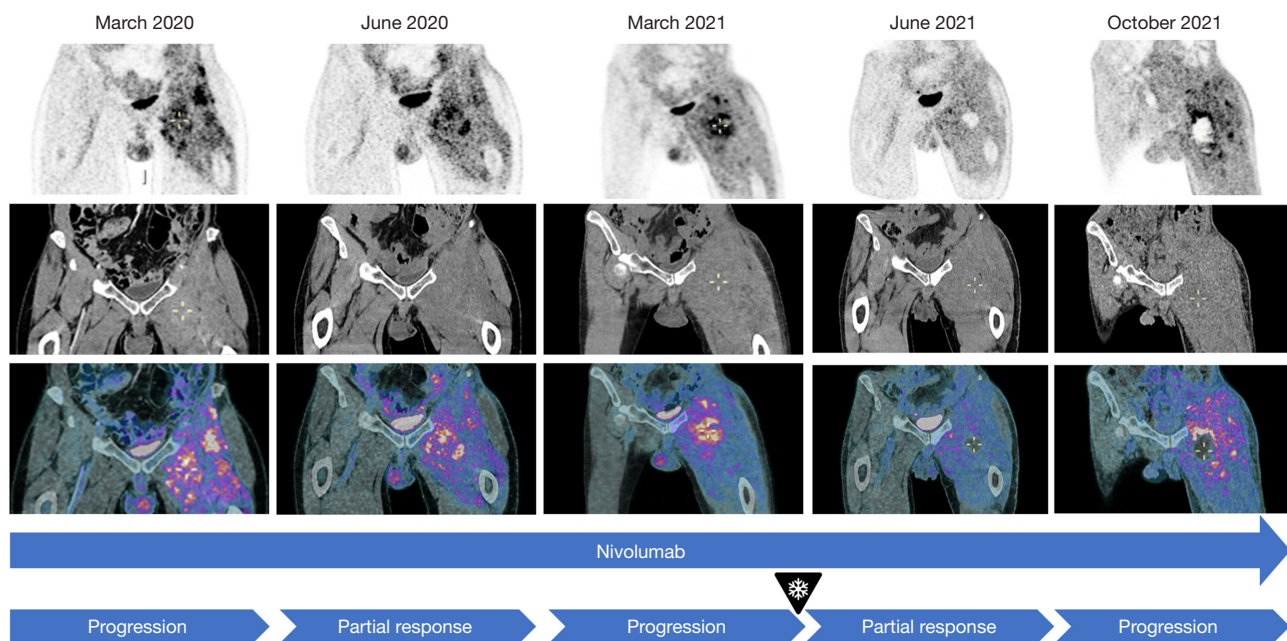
Treatment timeline and tumor response ¹⁸F-FDG PET/CT images showing evolution of left thigh involvement before/during immunotherapy and before/post cryoablation. ¹⁸F-FDG PET/CT, ¹⁸fluorodeoxyglucose positron emission tomography/computed tomography.
